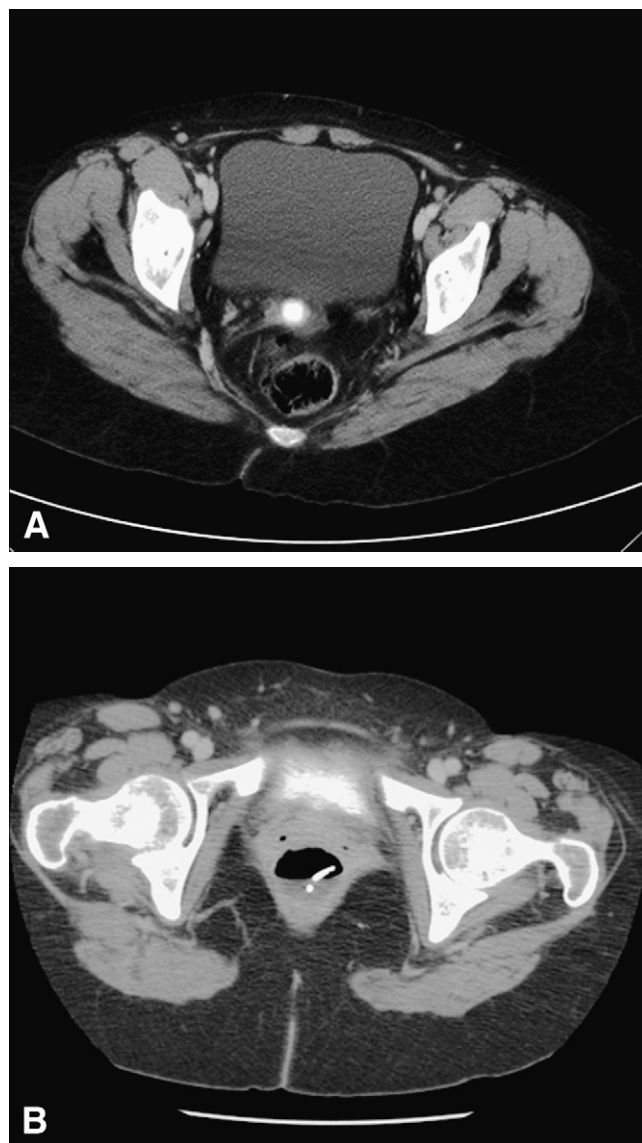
CT of the abdomen (axial view) reveals a large pelvic abscess measuring 9×8 cm (A). A follow-up CT scan at 36 hours after transrectal stenting reveals nearly complete resolution of the abscess (B).
